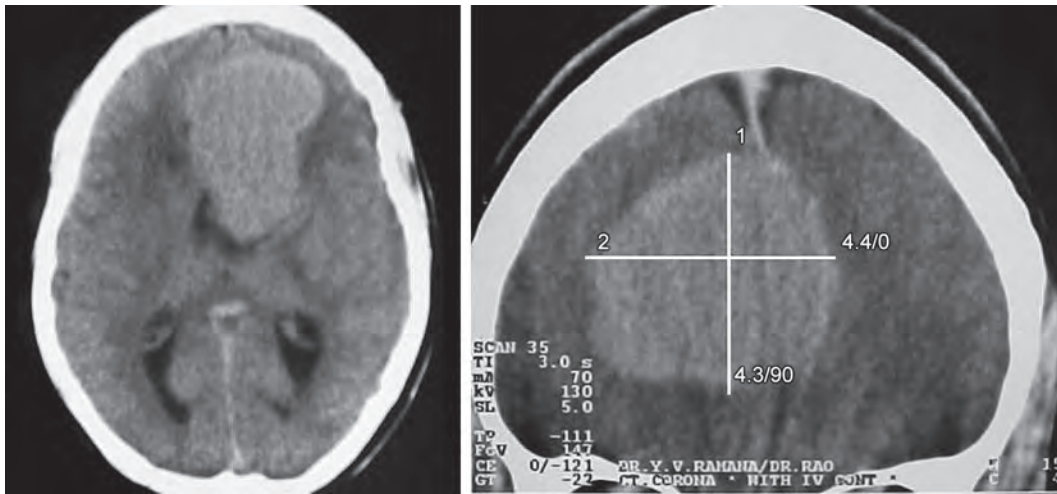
CT scan showing unilateral falx meningioma with mass effect
